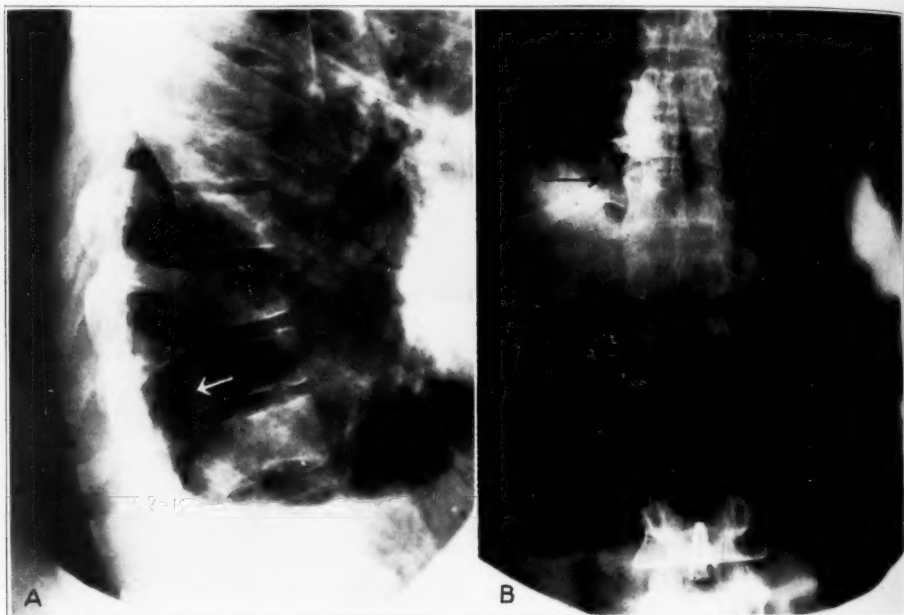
(case 4).—*A*, lateral roentgenogram of the spine; the white arrow indicates an enlarged intervertebral foramen between the ninth and tenth dorsal vertebrae, and the black arrow a pressure deformity of the spinous processes. *B*, anteroposterior view of the same region pictured in *A*. This demonstrates the erosion of the articular processes of the ninth and tenth dorsal vertebrae as indicated by the arrow, and narrowing of the tenth rib.
